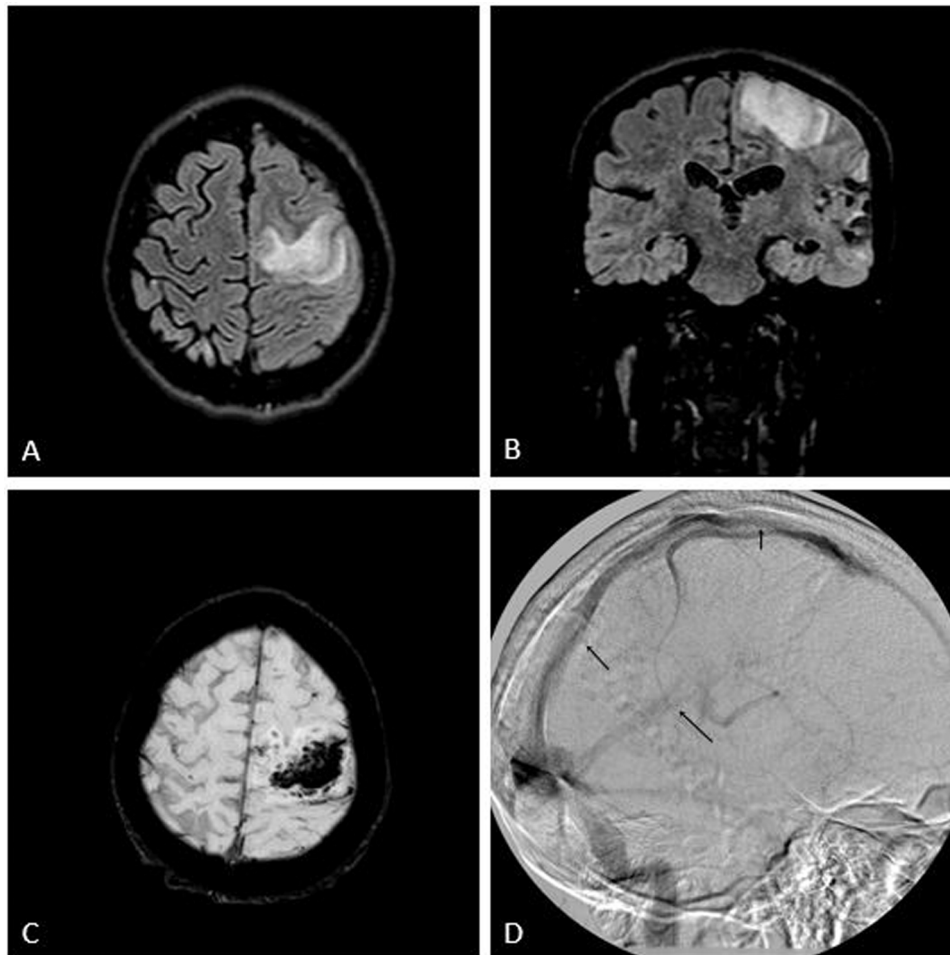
New AIS. (A-B) FLAIR and (C) SWI MRI imaging; (D) DSA showing CSVT (black arrows).
